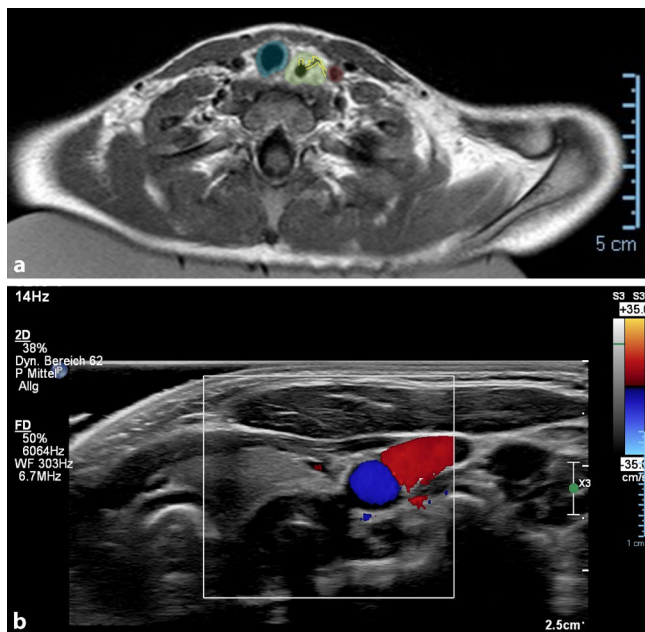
◀ a Preoperative magnetic resonance imaging (MRI) of transversal axis. Trachea (blue), edematous esophagus (green) with two duct-forming ulcerations (yellow lines), one of which extends into the vicinity of the common carotid artery (ACC, red). b Sonography with color-coded duplex sonography of the esophageal wall without recognizable separating structures to the ACC (color duplex, right blue, internal jugular vein red)
